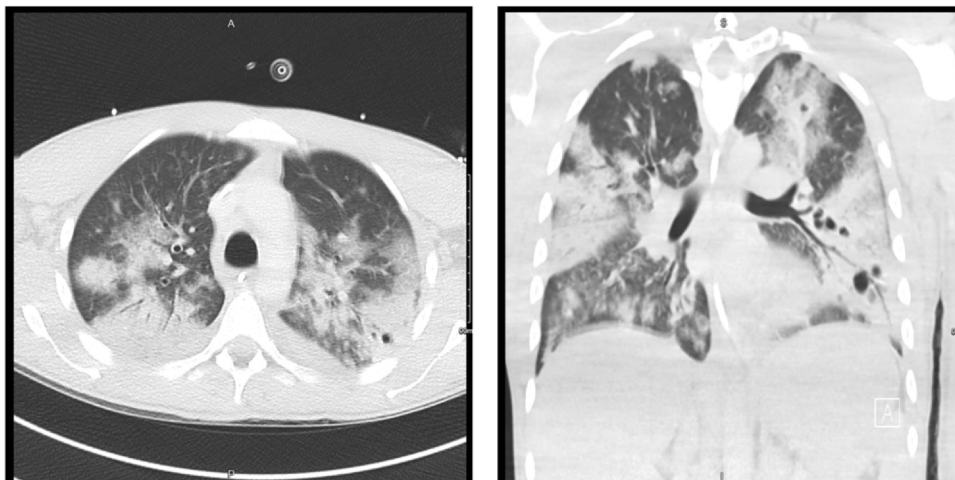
Chest CT performed on day 13 of admission demonstrating extensive perihilar ground-glass opacification with superimposed dense bilateral bibasal consolidations. Traction bronchiectasis and multiple pneumatoceles are present. Overall radiological appearance is consistent with alveolar destruction.
